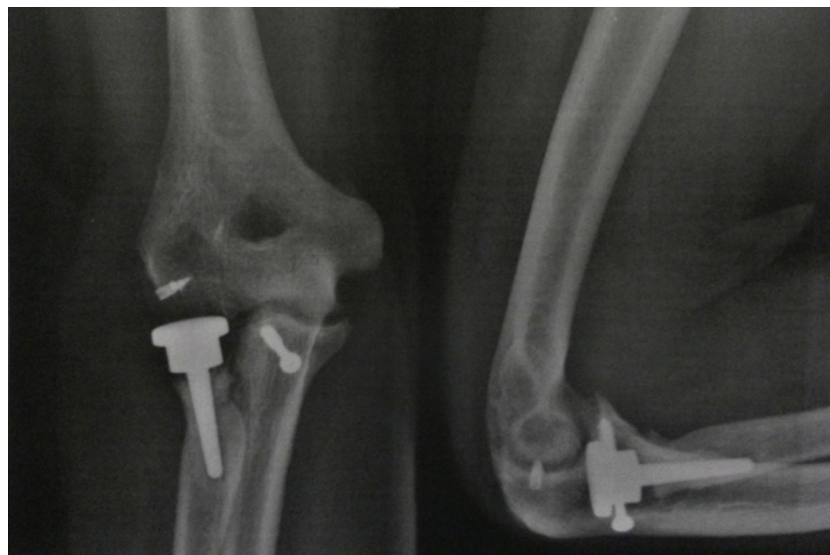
Front and lateral-view radiographs of the elbow demonstrating the results from the surgical treatment, with lateral ligament repair using an anchor, radial head prosthesis and osteosynthesis of the coronoid using a screw.
